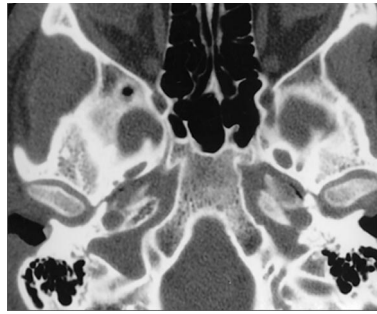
Fine section cranial base computed tomographic scan (bone windows). The right FO is more slender than the left and possesses a much thinner posterior wall. Such asymmetrical anatomy could predispose to ICA penetration during FO instrumentation.
